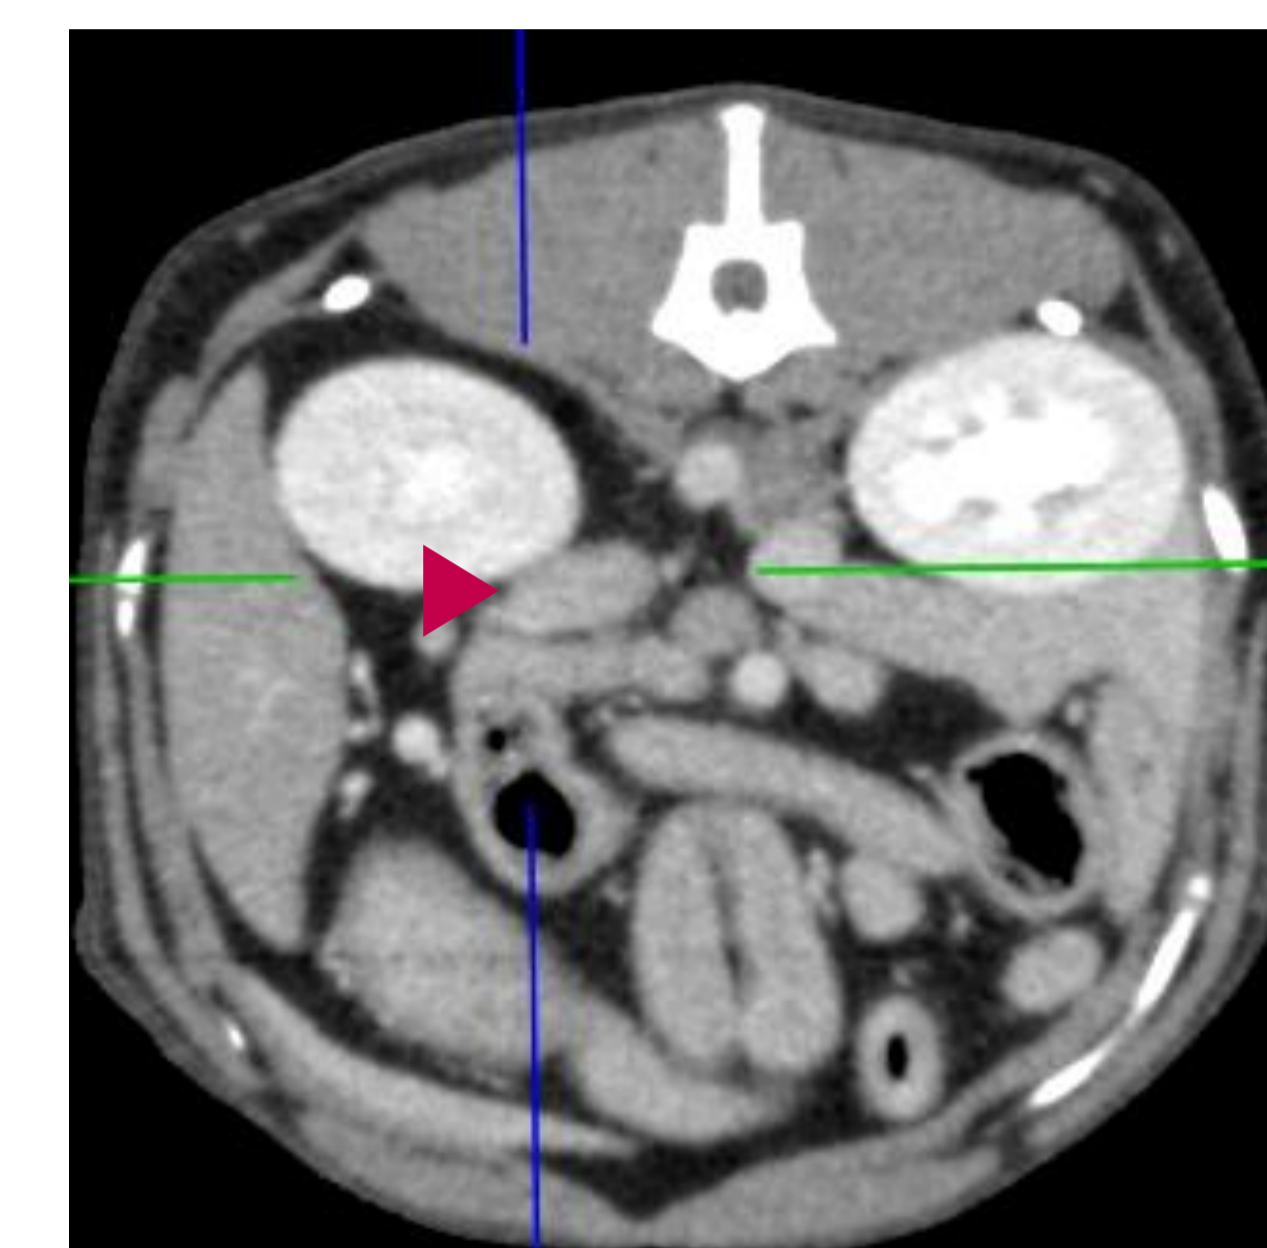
CT image showing moderate enlargement of the colic and splenic lymph nodes
